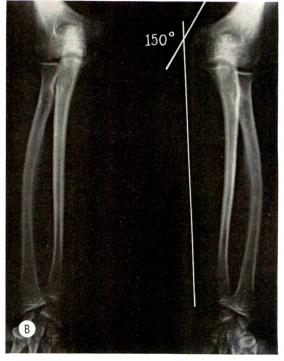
(B) Roentgenographic study of the elbows shows no localized bone abnormality. The roent-genographic evidence of cubitus valgus was less striking than the clinical appearance.
